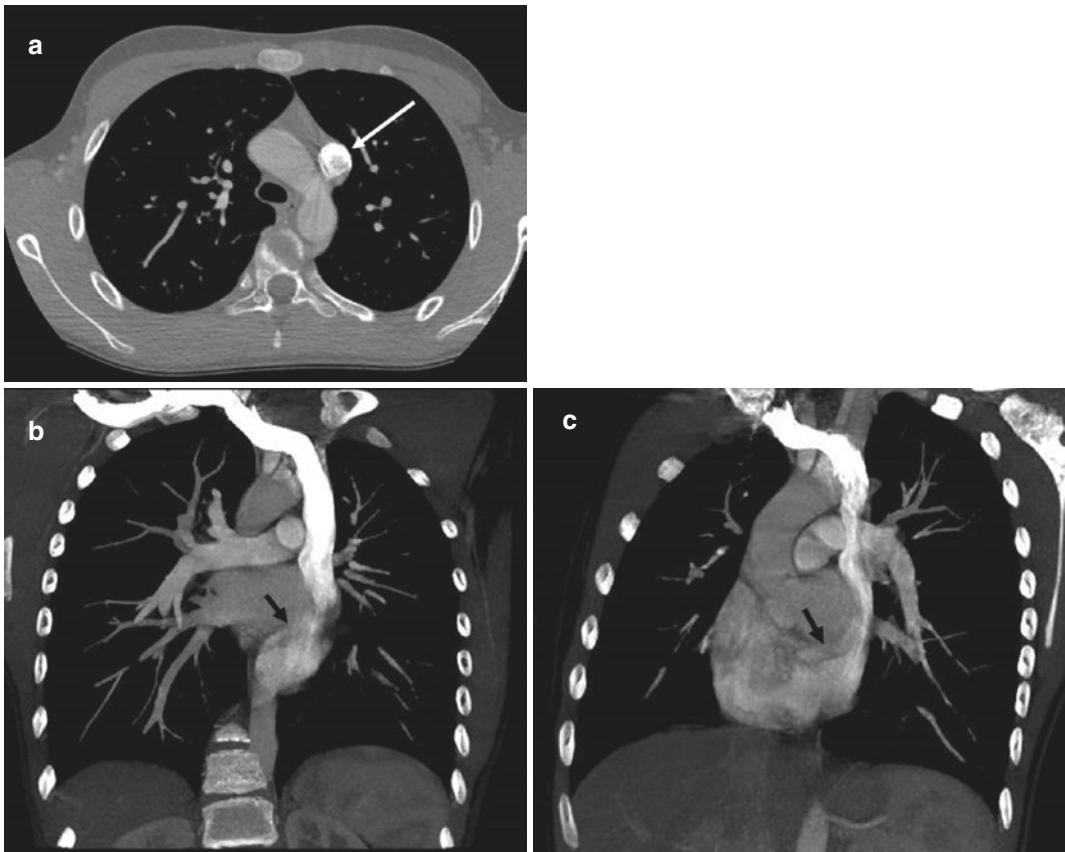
Persistent left superior vena cava (mirror image) at CT angiography. (a) Axial, (b) coronal oblique, and (c) sagittal oblique thin maximum intensity projection images
